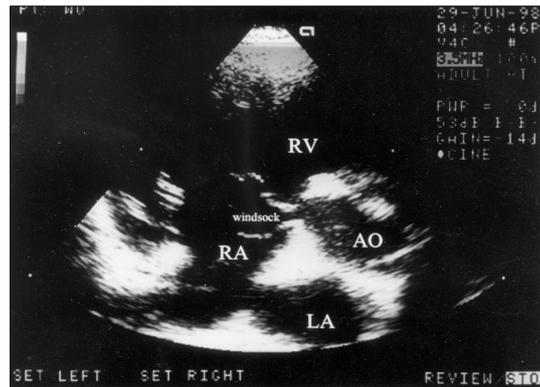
Transthoracic echocardiogram shows windsock-like aneurysm originated from right Valsalva sinus into right atrium in right ventricle inflow view.
